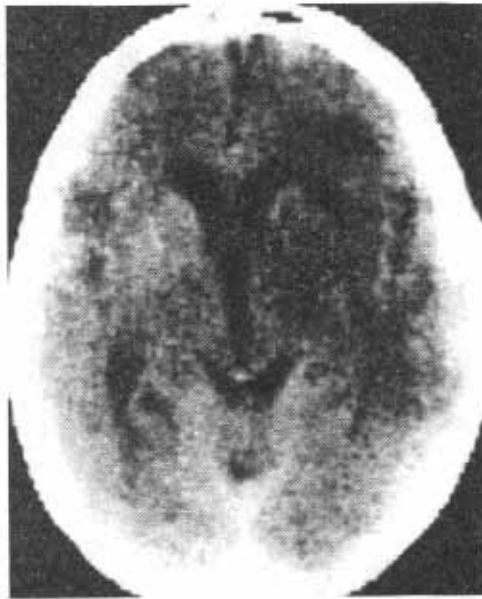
Post steroid therapy CT scan.
